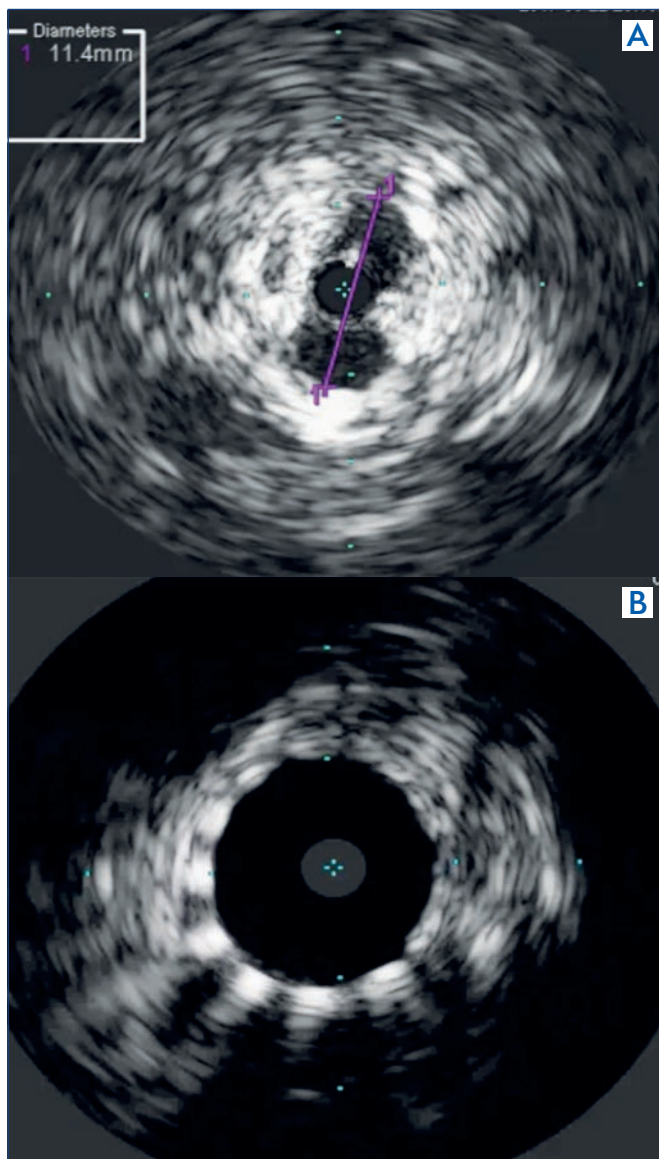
Intravascular ultrasound finding in a postthrombotic syndrome case.
